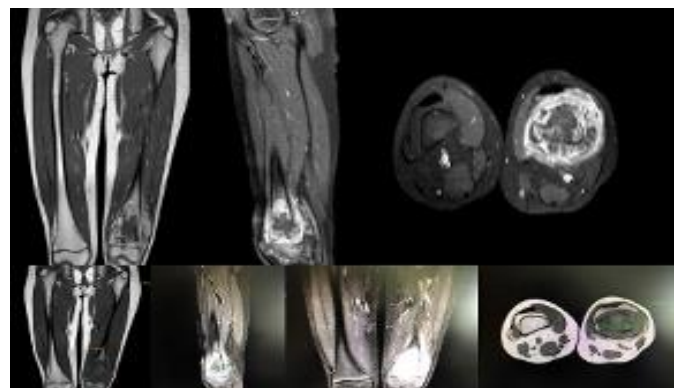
Magnetic resonance imaging [MRI (T1 and T2)] showing a large metaphyseal lesion with cortical destruction and a 67-mm soft-tissue mass displacing neurovascular structures
